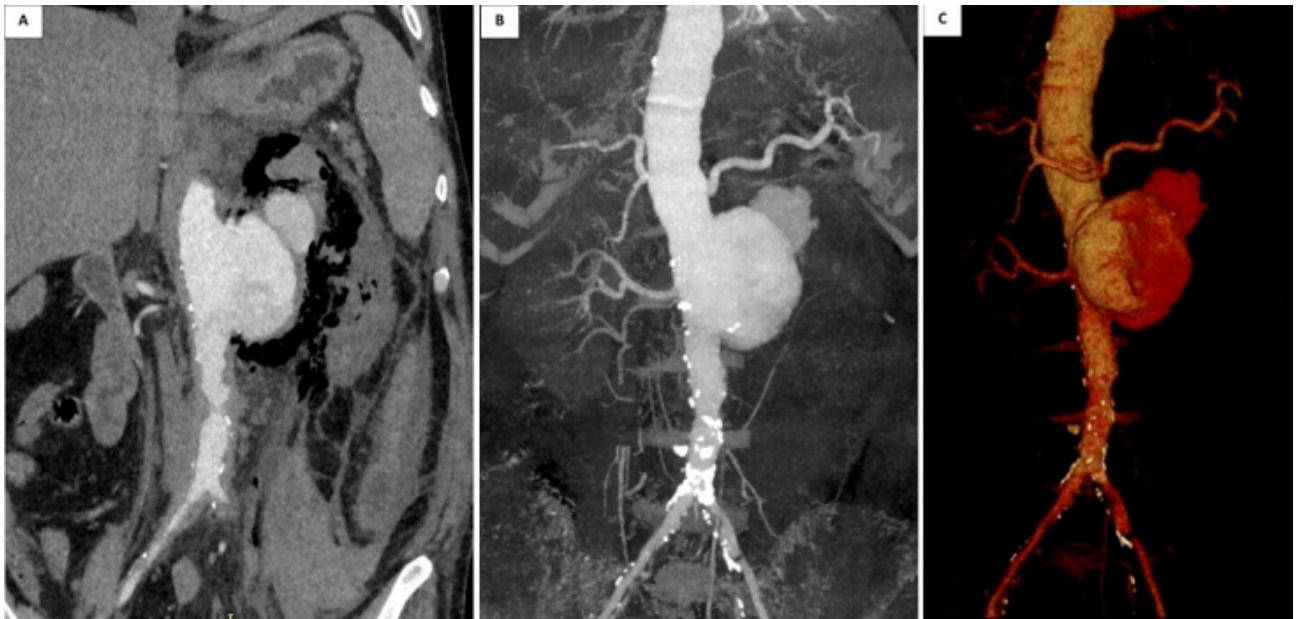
Coronal reconstruction of enhanced abdominal computed tomography scan (A) shows a free gas collection outlining the pseudoaneurysm. There are calcified plaques in the aorta with an irregular fringe. Coronal thin maximum intensity projection (MIP) computed tomography images (B) and volume rendered images (VRT) (C) showing saccular shape of the pseudoaneurysm, partially calcified aortic wall, and a normal right renal artery
